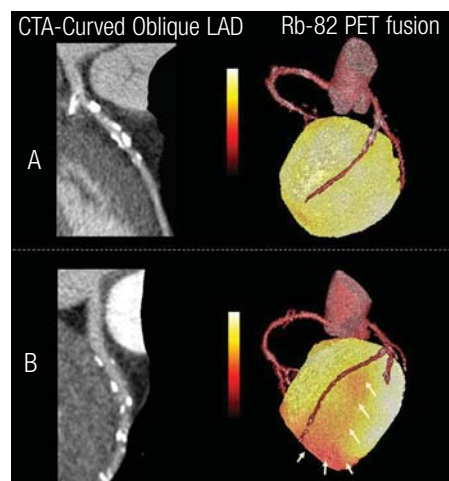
Two cardiac Rb-82 PET/CTA cases. CTA shows extensive calcifications in left anterior descending artery in both cases (left), associated with atherosclerotic plaques which were considered borderline occlusive in both cases. Fusion with perfusion PET (right) shows normal stress perfusion in case A, while there is extensive hypoperfusion in LAD territory in case B.
